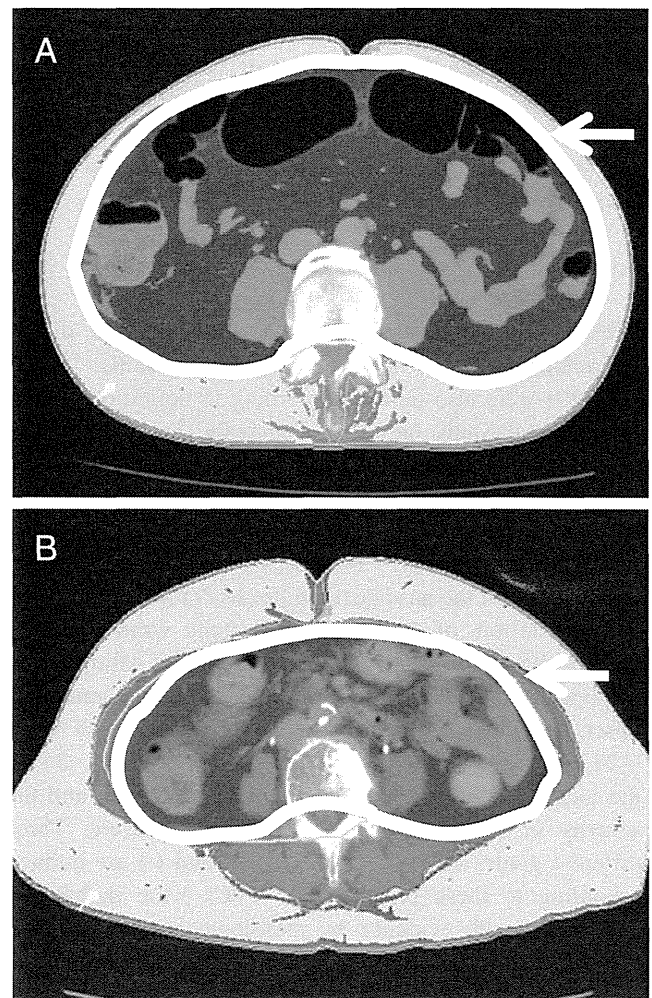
Distribution of visceral fat area (VFA) by FatScan software on preoperative CT scan. The white line (*white arrow*) outlines the intraperitoneal area. Visceral fat tissue was calculated in the region outlined by the white line by FatScan software. A, VFA was 194.4 cm² and body mass index (BMI) was 19.6 kg/m², representing high VFA but low BMI. B, VFA was 71.1 cm² and BMI was 25.3 kg/m², representing low VFA but high BMI (high VFA ≥ 130 cm² and low VFA < 130 cm² and high BMI ≥ 25 kg/m² and low BMI < 25 kg/m²)
